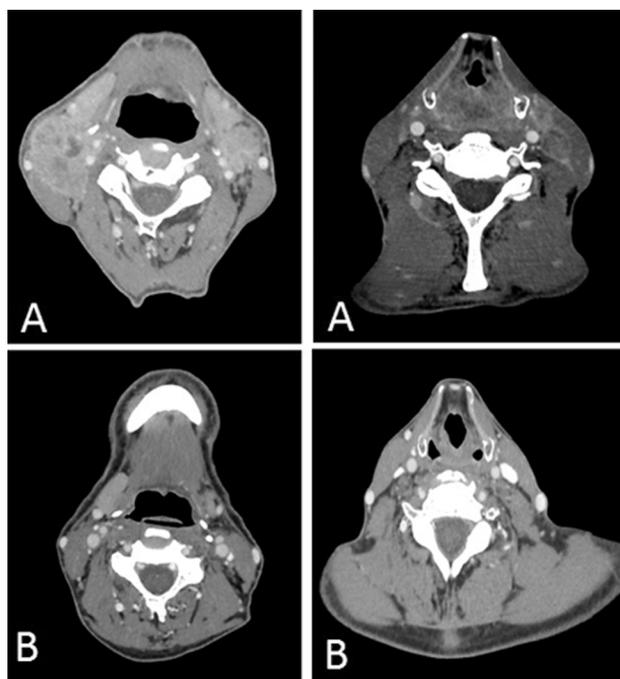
Computed tomography scan of disease progression after the first treatment with immune check point inhibitors (A), and after six cycles of cisplatin and fluorouracil (B).
